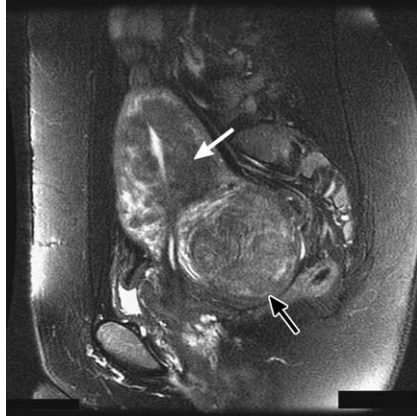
Sagittal T2-weighted image shows large subserosal fibroid emanating from the posterior wall (*black arrow*) with a thin peripheral rim (dilated veins or lymphatics). The thickened junctional zone indicates adenomyosis (*white arrow*).
